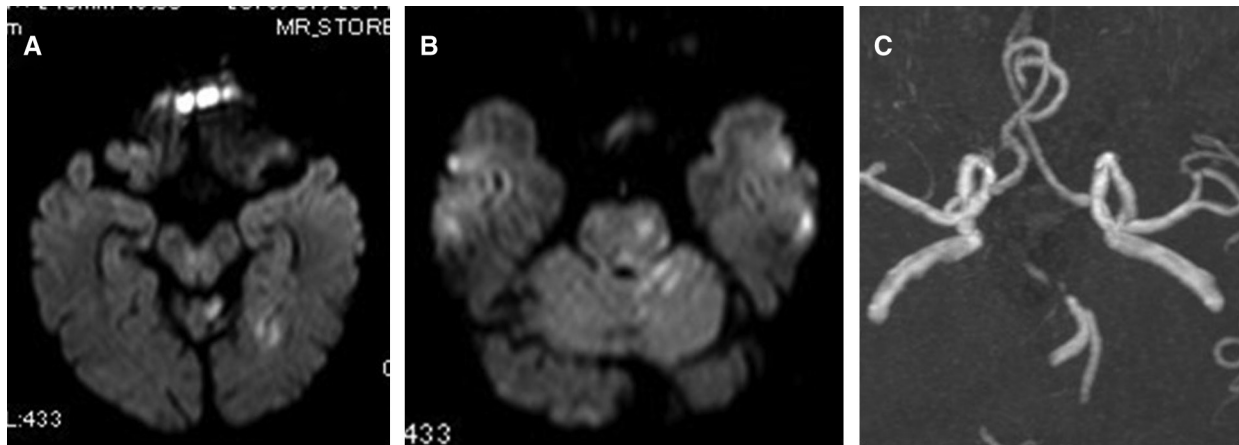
Pretreatment CT and MRI imaging. (A and B) Diffusion-weighted images show acute ischemic stroke partially in the pons, left cerebellar hemisphere, and left occipital lobe. (C) MRA
